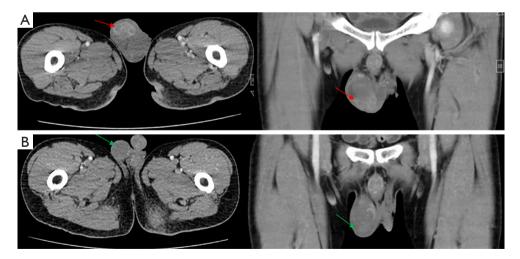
CT scan demonstrated that the right testicular metastasis before treatment (A), and the regression of tumor after ninth treatment cycle (B).
